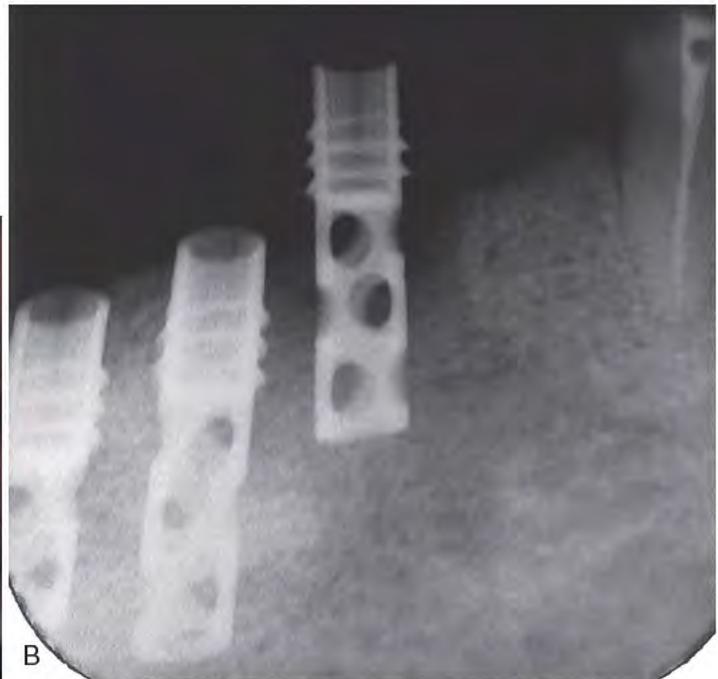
A, Occasionally, a two-stage submersible implant becomes mobile, loosens, and begins to extrude. B, A radiograph confirms the hopeless prognosis of this root form device.
